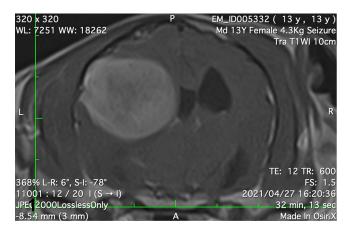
Heterogeneously strong tumor enhancement in the contrastenhanced T1-weighted imaging.
